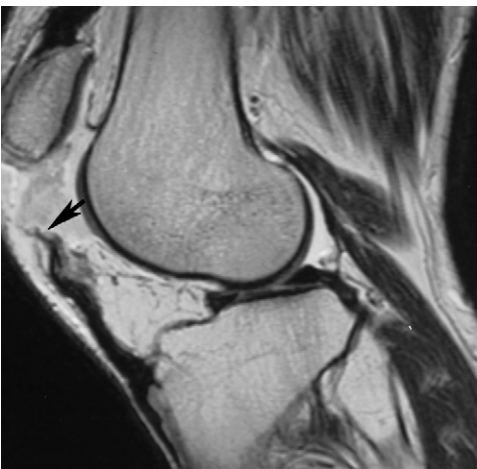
Complete patellar tendon tear. Sagittal T1-weighted image shows a wavy tendon with complete separation (arrow) at the patellar attachment and superior displacement of the patella.
